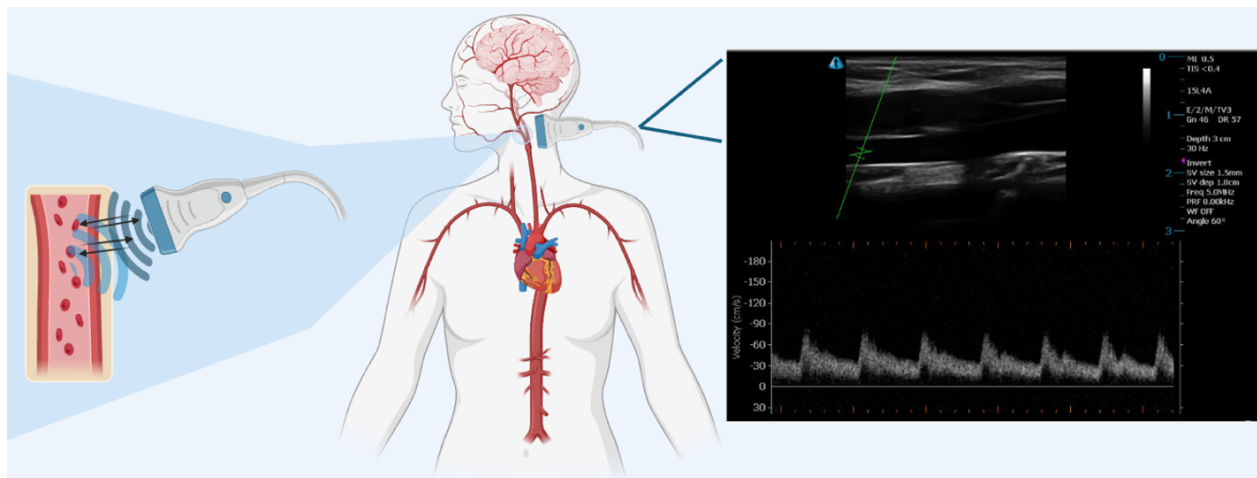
Vascular Duplex in the ICA. A depiction of insonating the internal carotid artery using vascular Duplex ultrasound. The far-left shows ultrasound pulse waves being transmitted from the transducer, encountering the moving red blood cells, and transmitting back to the transducer. On the far right is a *B*-mode image of the internal carotid artery where the green line=steering angle, dark are in the middle of the vessel=lumen, bright white outline of the lumen=vessel walls. Beneath the image of the vessel is the velocity trace (cm/s).
